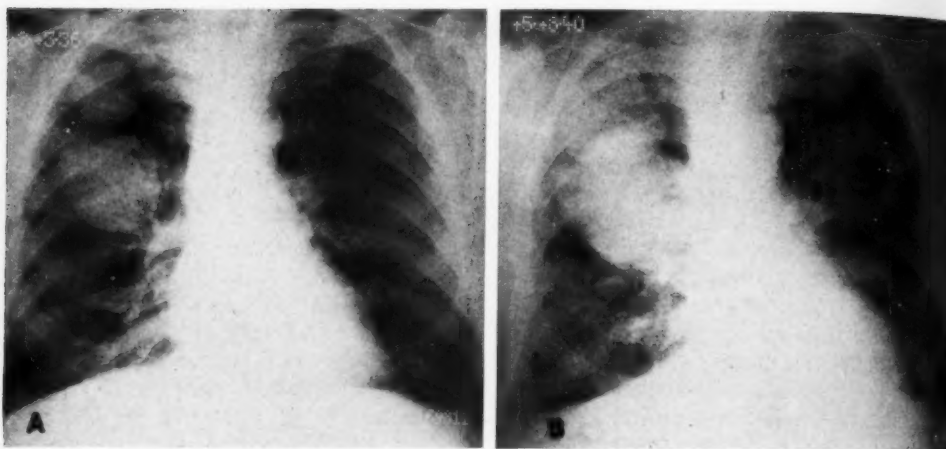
Case 1. A. Aug. 3, 1936. Pulmonary metastases from pseudo-adenomatous basal-cell carcinoma of the pharyngeal part of the tongue, discovered nine years after the first admission. No pulmonary symptoms. B. May 8, 1940. This roentgenogram was made three years and nine months after A. The metastases have increased in size and number but are still asymptomatic.
